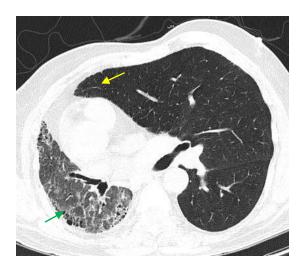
CT Non contrast lung window showed diffuse inter and intralobular septal thickening, ground-glass opacities, bronchiectasis, and honeycombing (green arrow). Compensatory hyperinflation of left lung herniating across the midline (yellow arrow).
